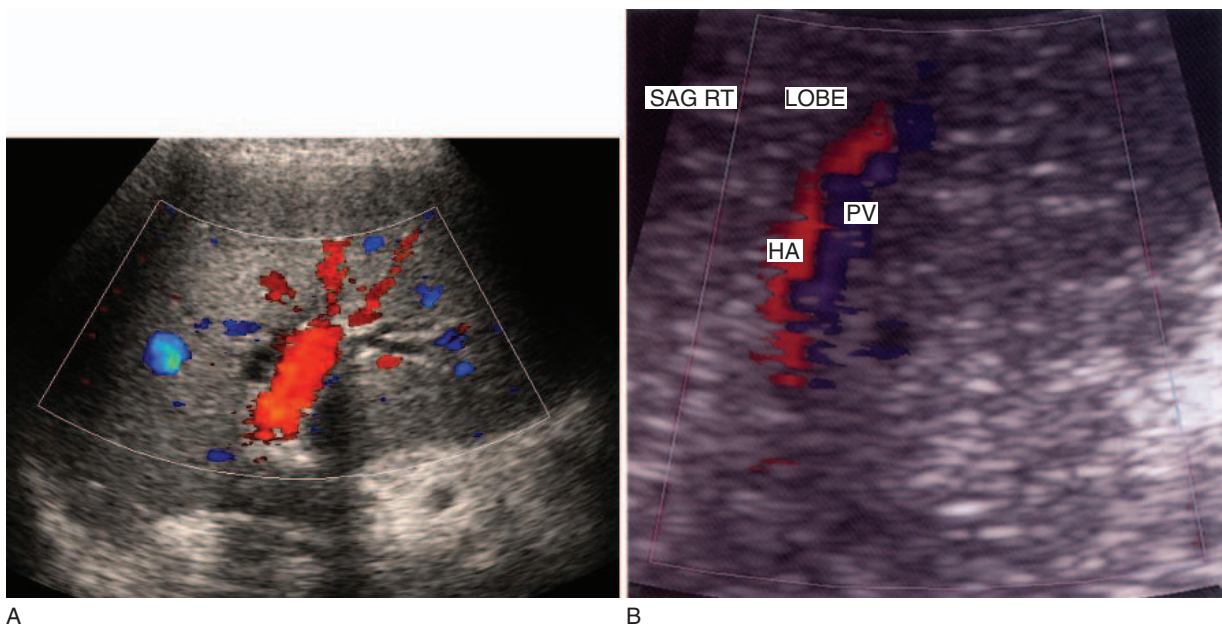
(A) Dilated biliary ducts do not demonstrate flow on colour Doppler, differentiating them from portal vessels. (B) Originally suspected as a dilated biliary tree, colour Doppler demonstrates that the 'extra tubes' are, in fact, dilated intrahepatic arteries in a patient with end-stage chronic liver disease with reversed portal venous flow.
